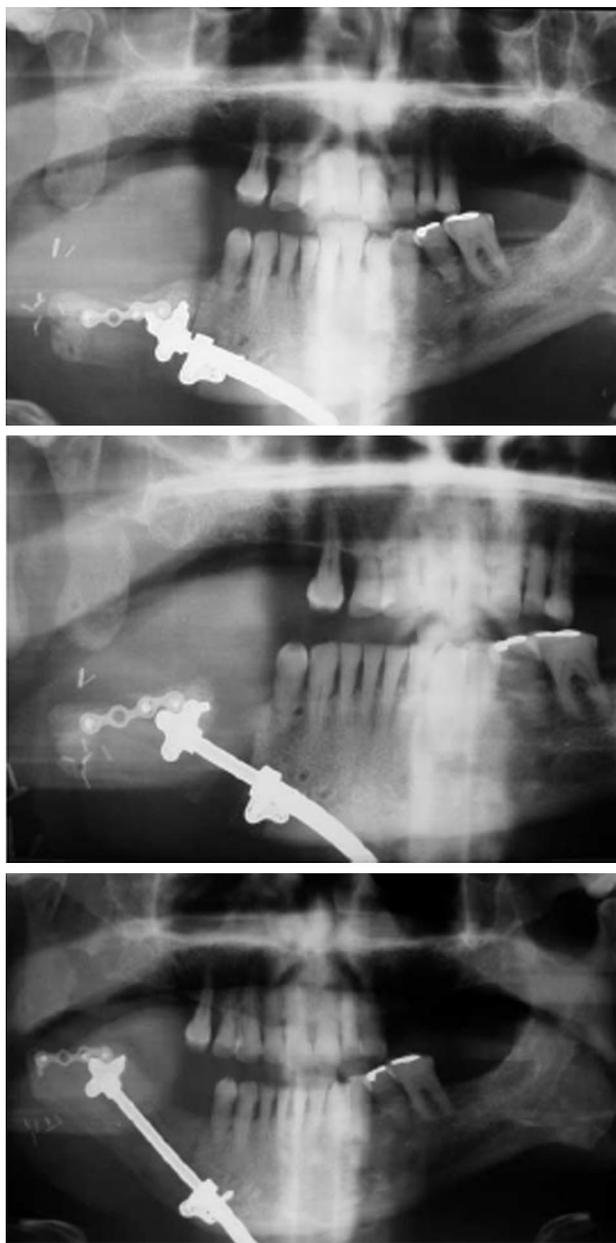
Panoramic radiography. Second distraction osteogenesis: distraction of the entire mandibular body. (Above) At the beginning of distraction. (Center) Midpoint of distraction. (Below) At the end of distraction.
